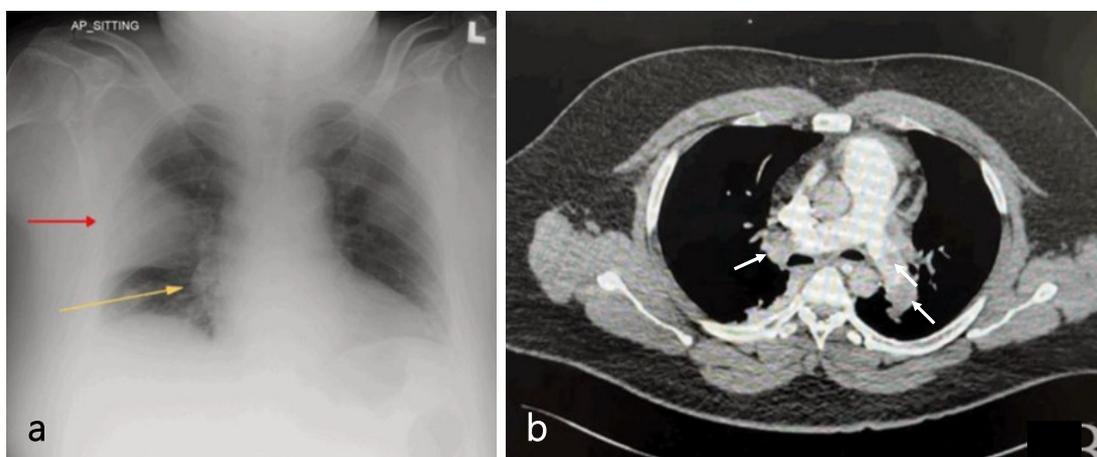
a) Chest X-ray showing Hampton's hump (yellow arrow) and Palla's sign (red arrow), b) Axial CTPA image confirming an intraluminal right pulmonary artery embolus and also embolism affecting the left pulmonary artery (White arrows).
